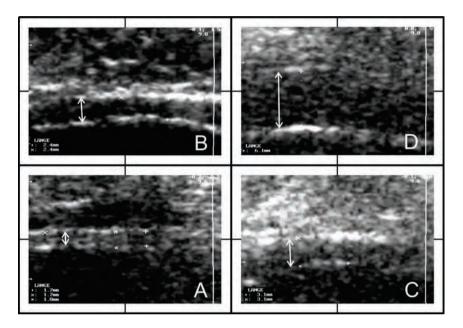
Ultrasound measurements of DWT. The mucosa (lower line) and adventitia of the bladder (upper line) appear hyperechogenic; the hypoechogenic area between those lines represents the detrusor and DWT (\updownarrow). The figure shows DWT measurements of 4 BPH patients (all 9.8 enlarged). A: No BOO (A1, DWT 1.7-1.8 mm), B - D: Varying degrees of BOO (B: B3 obstruction with a DWT of 2.4 mm; C: C1 obstruction with a DWT of 3.1 mm; D: D4 obstruction with a DWT of 6.1 mm).
